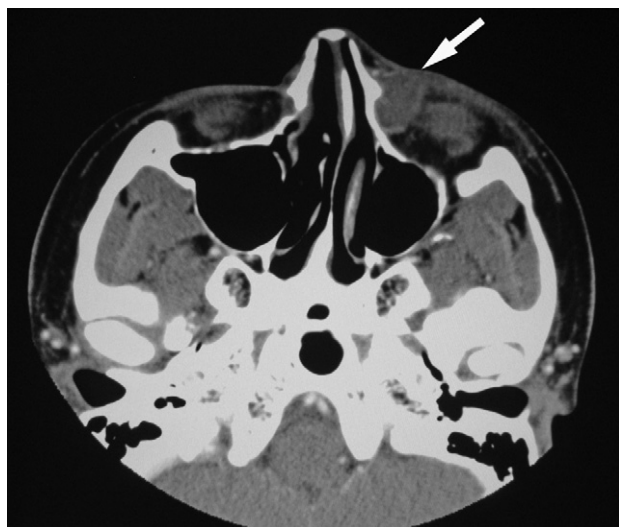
Axial computed tomographic scan with contrast showing a heterogeneous mass in the area of the left lacrimal sac, with enhancement of the rim and no bone invasion.
